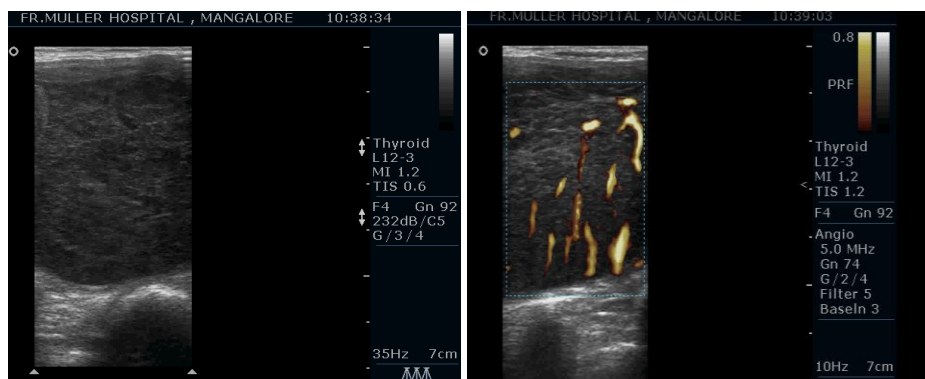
Follicular carcinoma of the thyroid (A) Gray scale (B) Doppler
